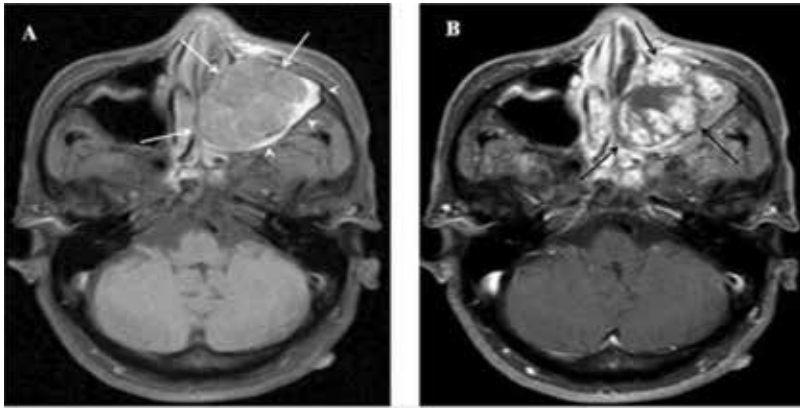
(A) Axial scan shows T1-weighted image with intermediate signal intensity lobulated mass lesion (white arrows) in the left maxillary sinus. Obstructed left maxillary sinus have high signal intensity sinonasal secretions (arrowheads). (B) Enhanced T1-weighted image shows heterogeneous intense enhancement (black arrows).
